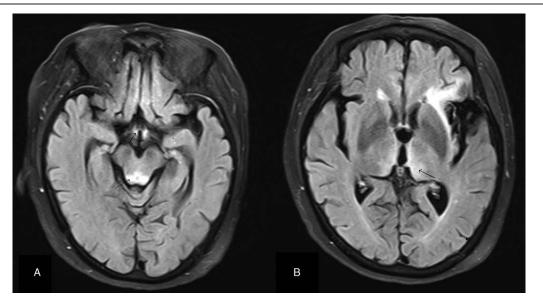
Brain MRI FLAIR demonstrating the symmetric lesions of hyperintensity at the periaqueduct and mammiliary bodies (A, arrow) and thalamic areas (B, arrow). FLAIR=fluid attenuated inversion recovery, MRI=magnetic resonance imaging.
